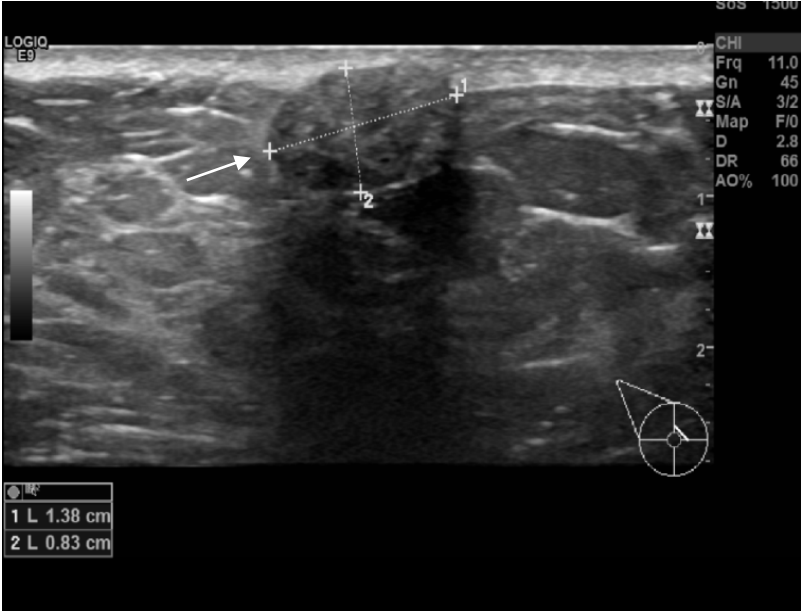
Ultrasound of the right breast demonstrating well defined subcutaneous homogenous hypoechoic oval lesion measuring 1.4 x 0.8 cm at 3 o'clock with a 0.5 cm distance from the nipple.
